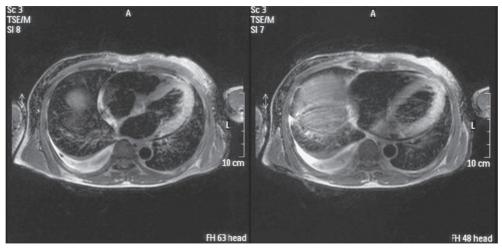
Cardiovascular magnetic resonance imaging with gadolinium of case 2
